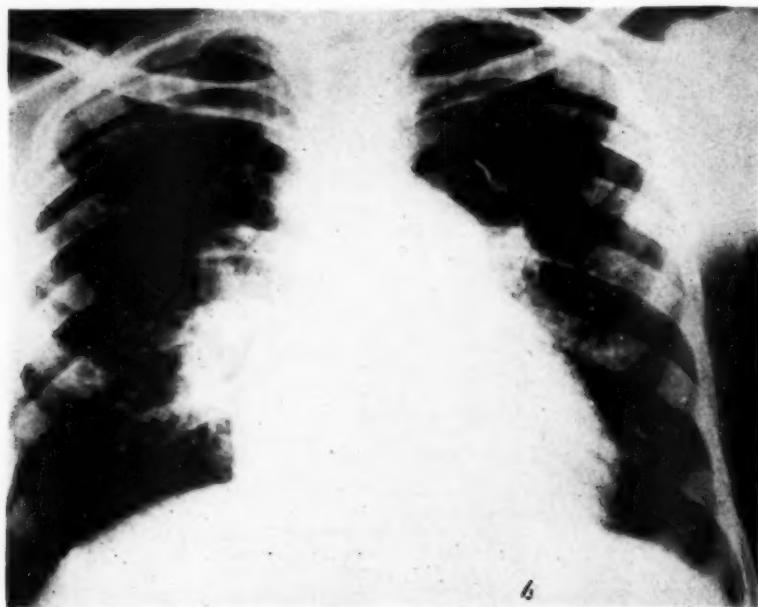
Roentgenogram of Patient 3. The pulmonary conus is enlarged and the aortic knob is absent. The right branch of the pulmonary artery is dilated. The mottling in both lungs is suggestive of bilharzic infiltration.
